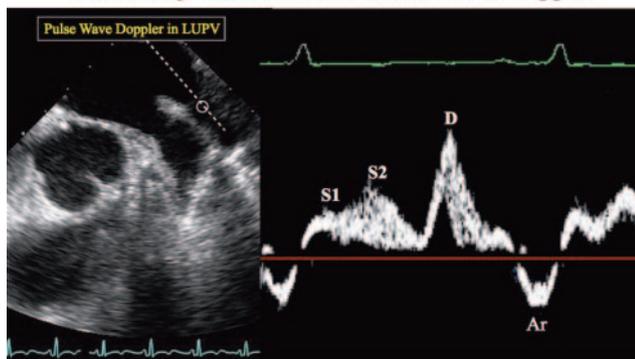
Pulse wave Doppler of the left upper pulmonary vein (LUPV). S1 = systolic 1 wave caused by left atrial relaxation; S2 = systolic 2 wave caused by right ventricular systole; D = diastolic wave; Ar = atrial reversal wave caused by atrial systole.
